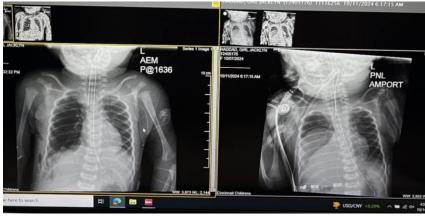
Radiographic analysis of a CDH patient
